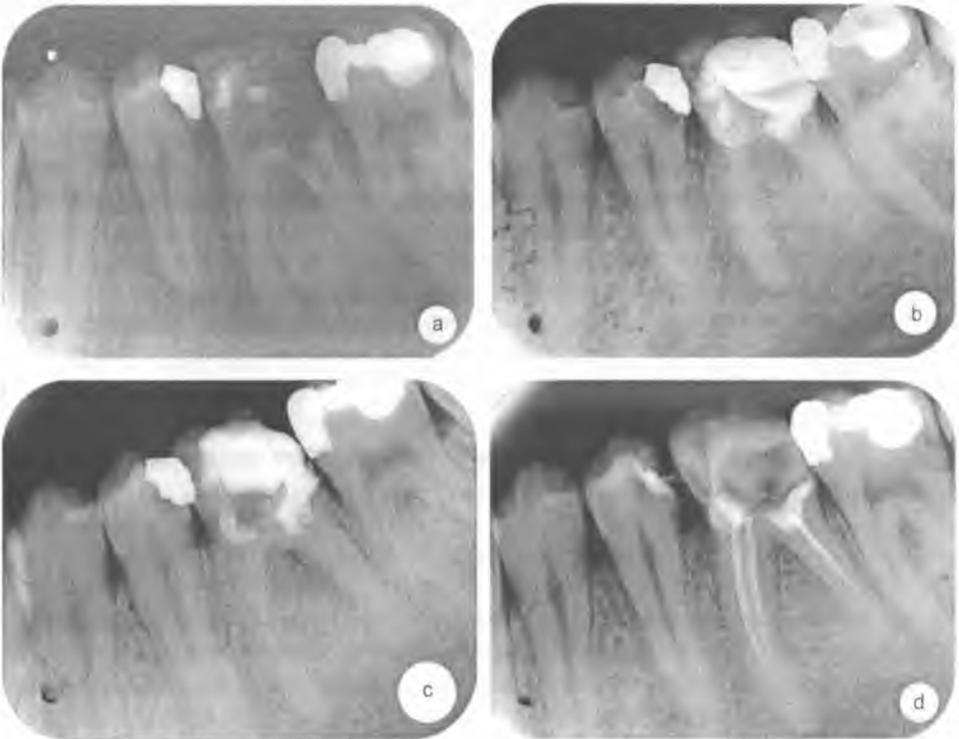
Patient D. M., male, age 29. Diagnosis: *periodontitis periapicalis chronica exacerbata*, tooth 46, radiograms: a – before treatment; b – after 3 months, c – after 6 months; d – after 9 months of treatment
